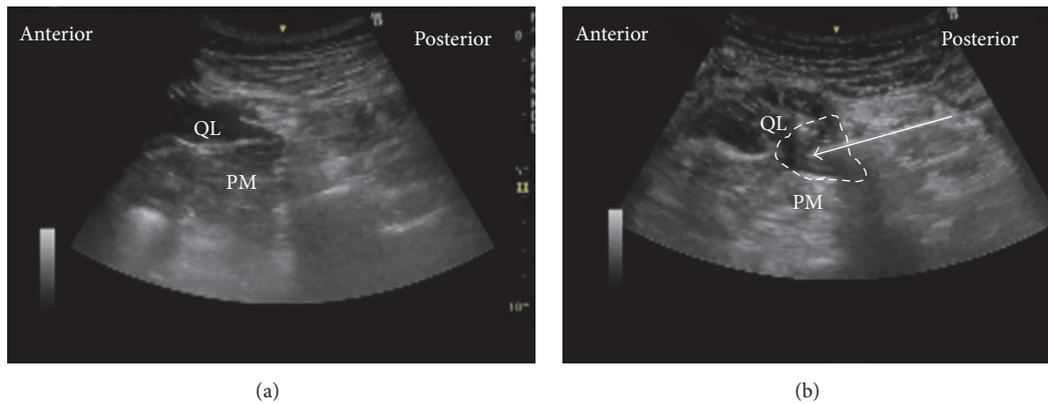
Ultrasound images of anterior QL block. (a) Preinjection and (b) postinjection. QL: quadratus lumborum, PM: psoas muscle, white arrow: needle trajectory, and white dotted line: spread of local anesthetic.
